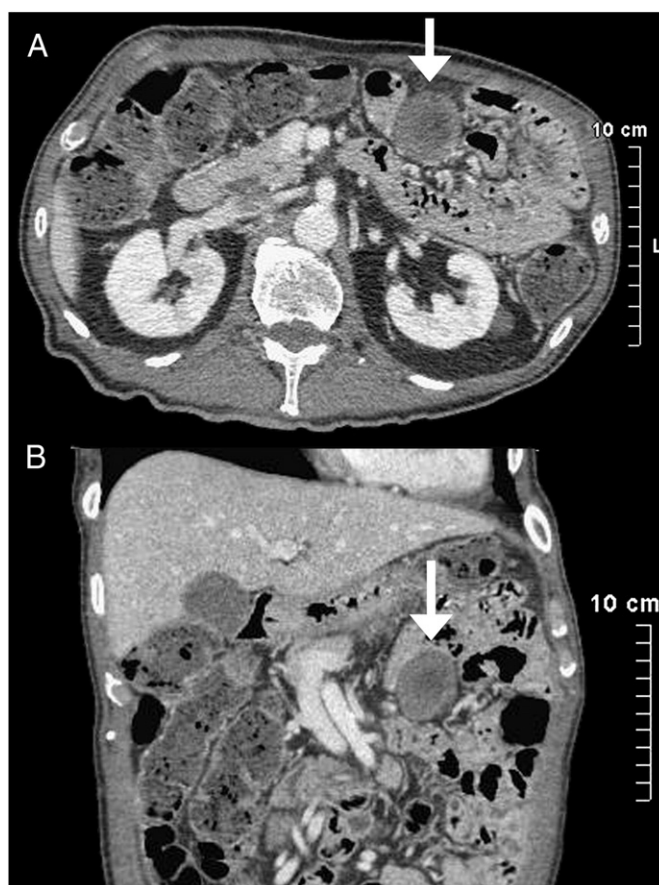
CT scanning of abdomen (A, horizontal; B, sagittal) showing a well circumscribed tumor mass related to the mesentery of the small intestine (arrows) with central hypodensity.
